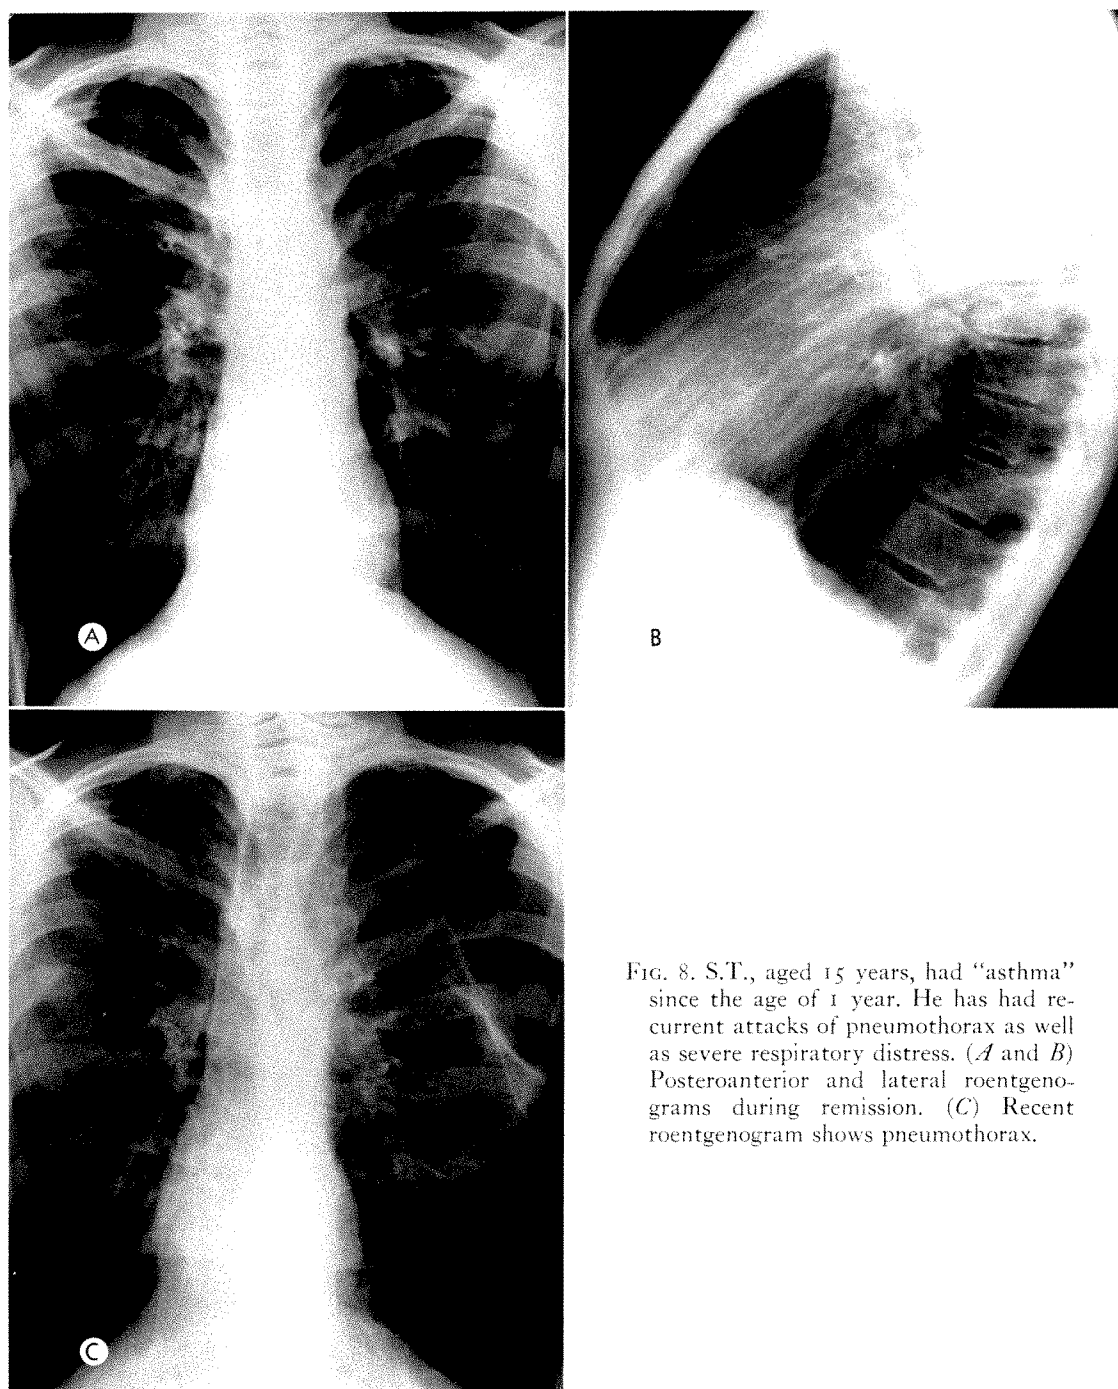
S.T., aged 15 years, had "asthma" since the age of 1 year. He has had recurrent attacks of pneumothorax as well as severe respiratory distress. (A and B) Posteroanterior and lateral roentgenograms during remission. (C) Recent roentgenogram shows pneumothorax.
